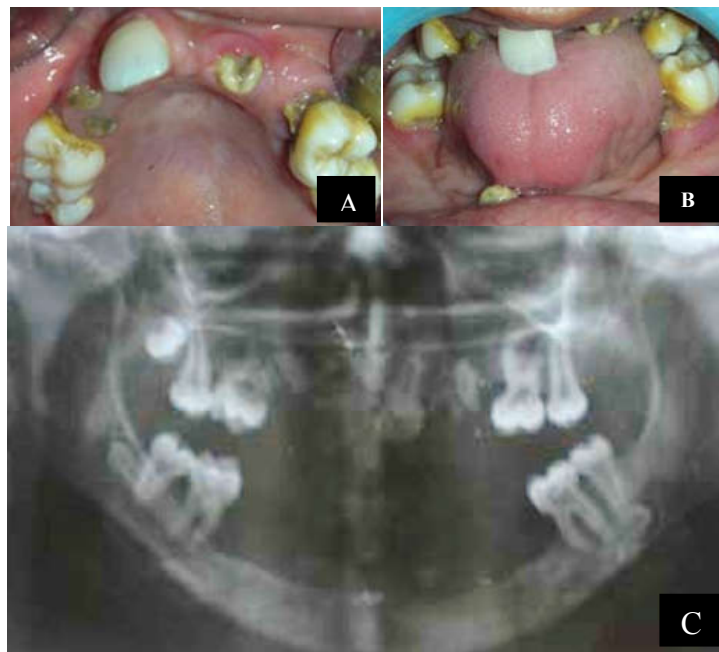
Photograph and X-ray of Case 6: A 15-year-old girl with PPH (37). A: Photograph of the maxillary arch. B: Photograph of the mandibular arch. C: Panoramic X-ray showing the absence of several teeth and the presence of large pulp chambers at the level of the molars in addition to a reduced bone level
